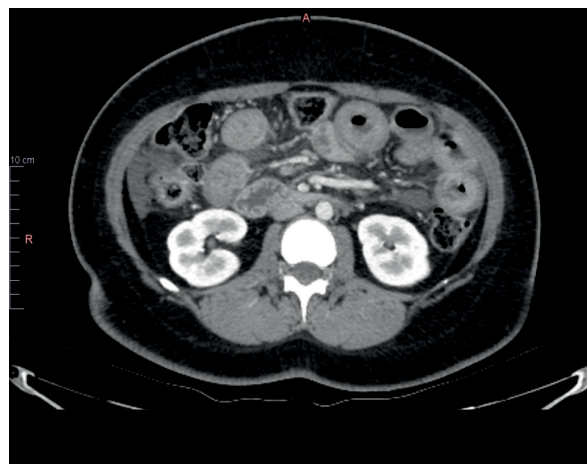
CT scan of the abdomen of a 28-year-old woman with hereditary angioedema type 1. Arterial phase.
